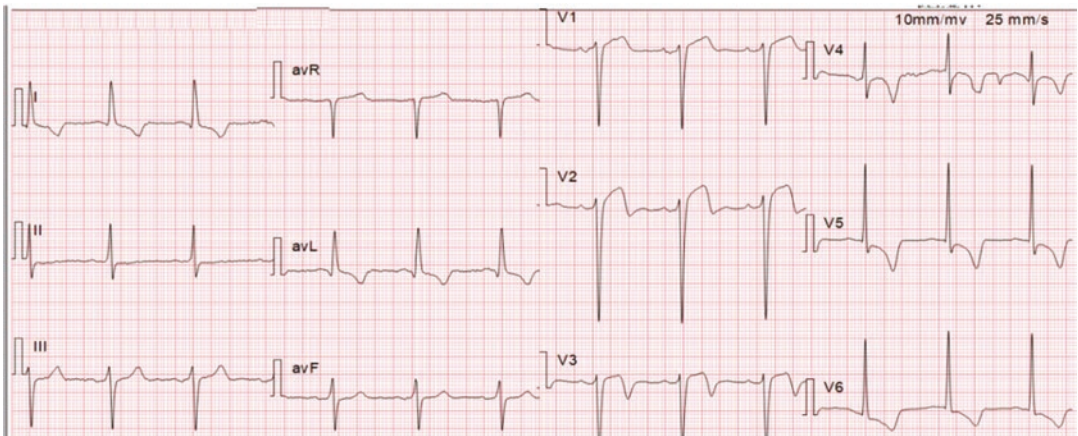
Sinus rhythm, QTc interval was 468 ms, and the interval was prolonged (male, 14-year-old, fulminant myocarditis, heart failure, echocardiography showed ventricular enlargement)
